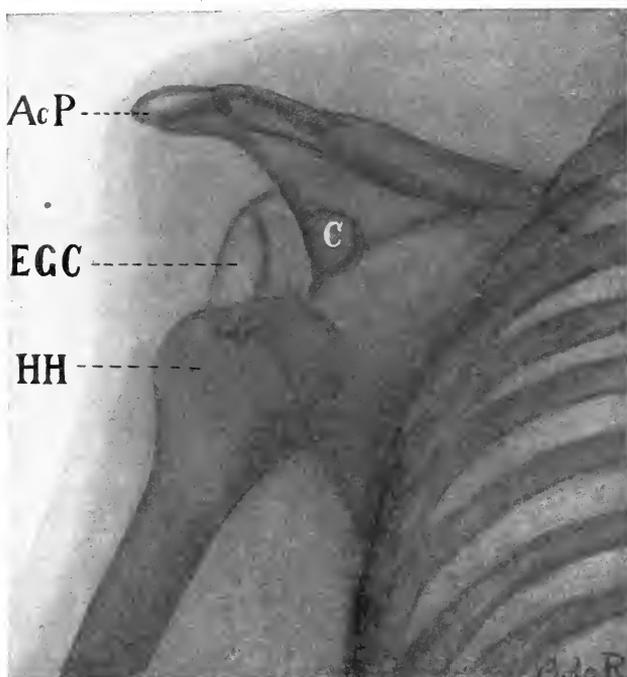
X-RAY OF SUBCORACOID DISLOCATION OF THE SHOULDER-JOINT.
